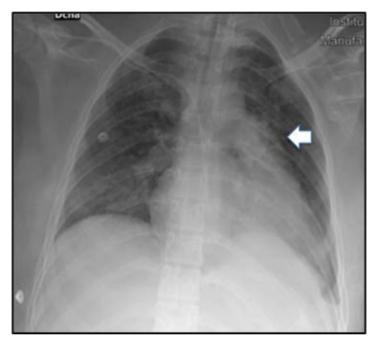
Portable chest X-ray showing diffuse pulmonary infiltrates, dextrorotation, and pulmonary artery dilation (white arrow).
